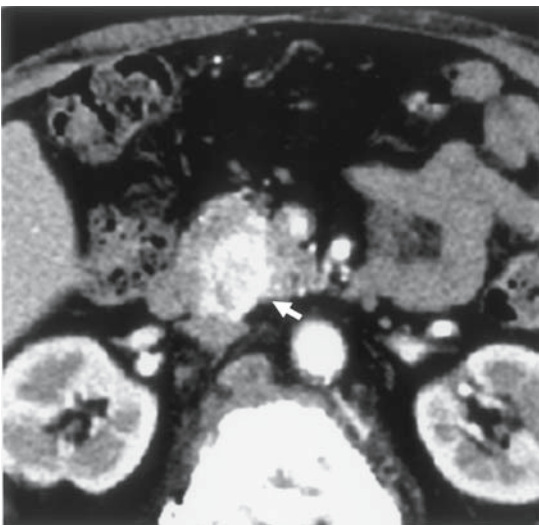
Imaging findings of a PET with clear cell cytology (CE-CT, early phase). Postcontrast CT imaging performed in the early phase shows that a well-circumscribed mass (arrow) in the head is highly enhancing and clearly distinguished from the surrounding pancreatic tissue.
